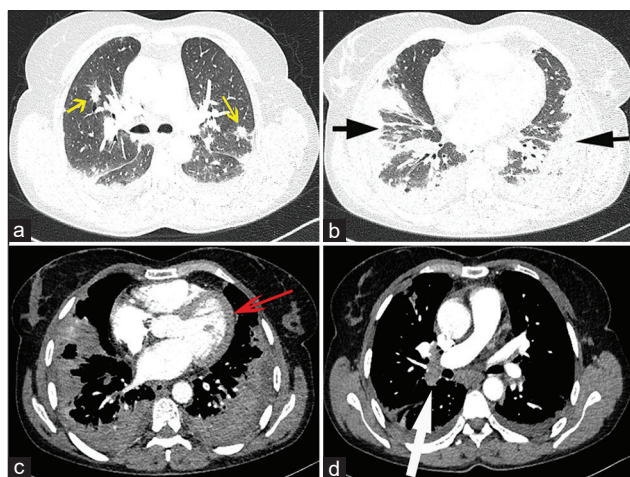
(a) Pulmonary nodules surrounded by ground-glass opacity, shown by a yellow arrow (b) Bilateral subpleural consolidations, shown by black arrows (c) Pericardial effusion, shown by a red arrow (d) Hilar lymph nodes, shown by a white arrow, in chest computed tomography
